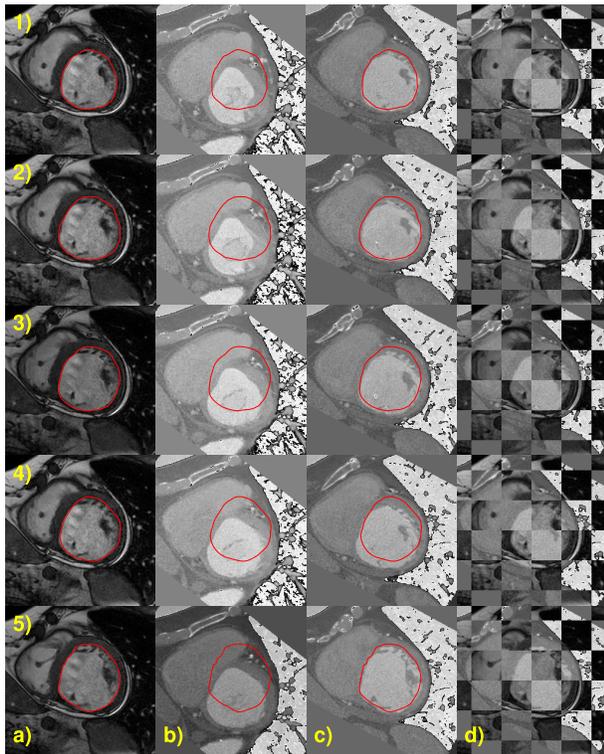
Registration results presented for the 5 frames analyzed (from top to bottom): a) SAX image, b) CT image resampled to the SAX plane after center alignment, c) CT image resampled to the SAX plane after registration, d) checkerboard SAX and registered CT. Endocardial contours traced on SAX plane are superimposed to correspondent CT plane before (b) and after (c) registration process.
